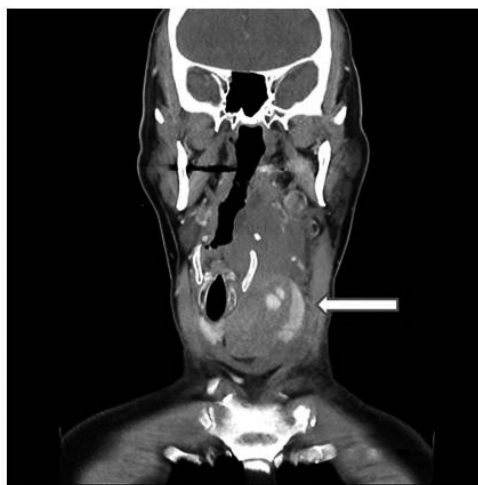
Contrast-enhanced computed tomography scan of the neck reveals a hematoma and pseudoaneurysm with active contrast extravasation over the left neck with tracheal deviation (arrow) in the reformatted coronal view (arrow).
